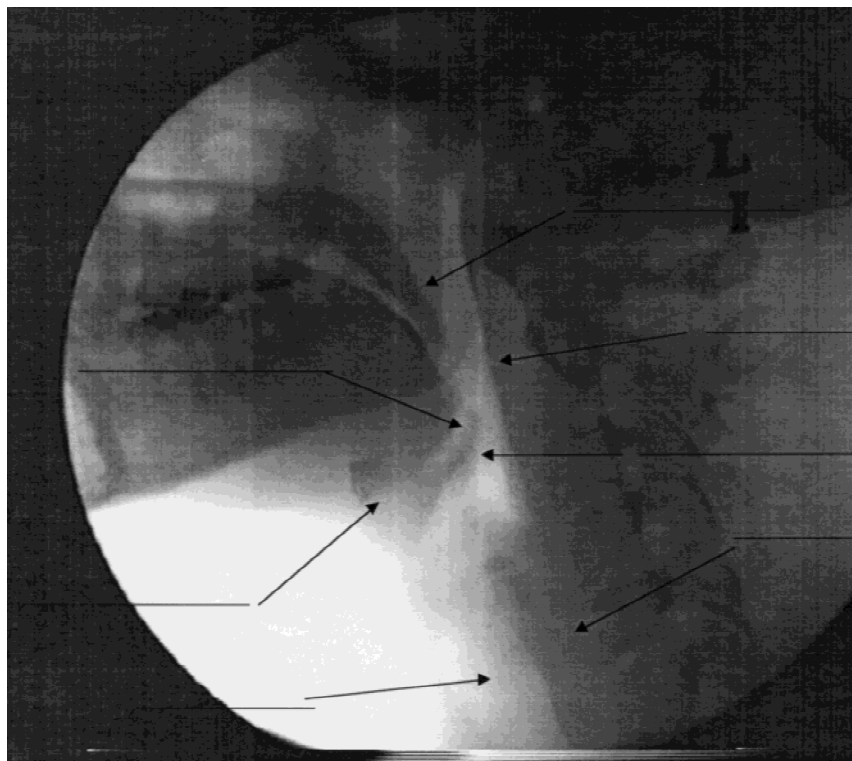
Radiograph for labeling structures.
